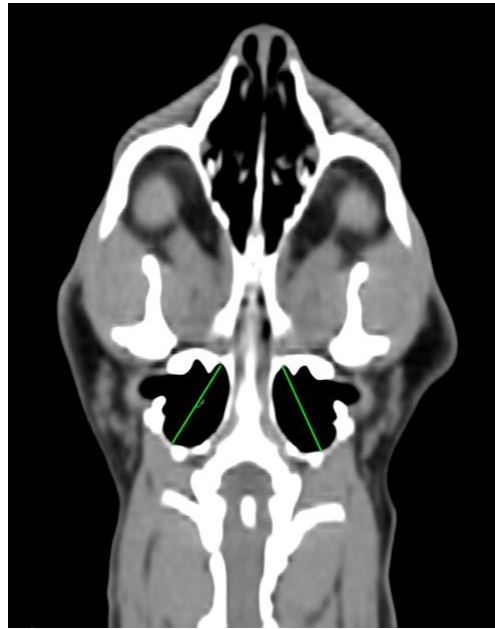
A CT image depicts tympanic bulla length measurement (green line) in the dorsal plane.
